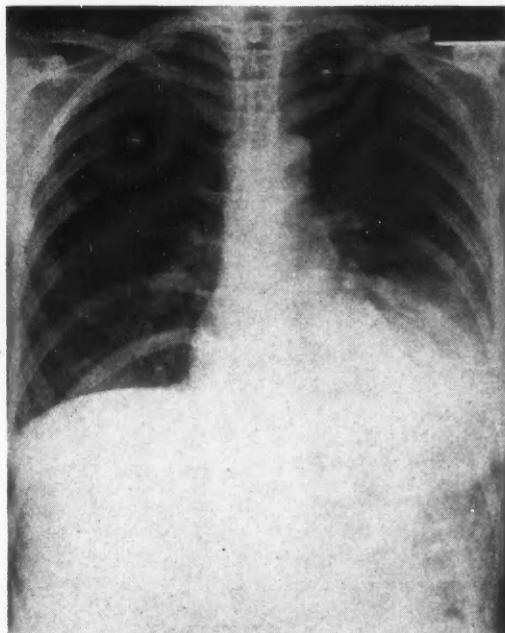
Roentgenogram of the chest taken on day of admission to hospital, showing pneumonia at left base.
